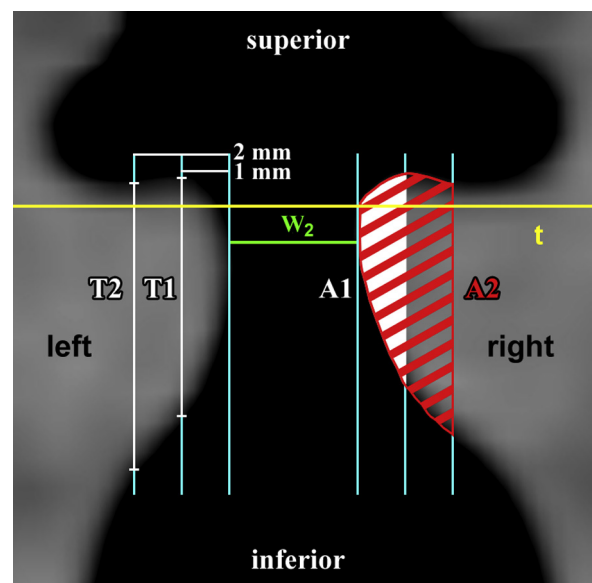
Scheme of the CT coronal plane used for the measurement of the vertical thicknesses (T1, T2), areas (A1, A2), and the glottal width w_2 ; t , transverse plane.
